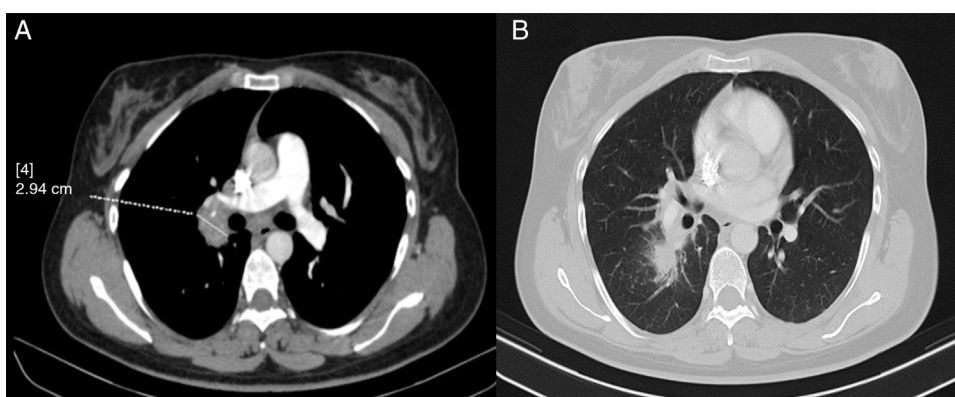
Axial images from chest CT scan with intravenous contrast. (A) Mediastinal window. (B) Lung window showing paratracheal, hilar, intrapulmonary and subcarinal lymphadenopathy of a pathological size, measuring up to 2.9 cm.
